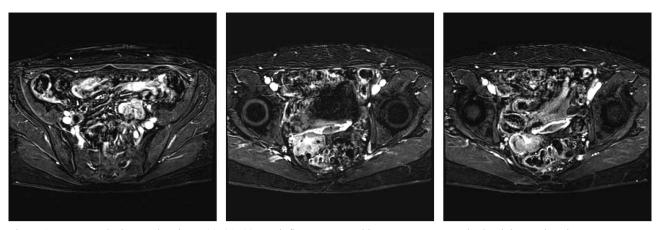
Presurgical MRI showing a 44×31×39 mm inflammatory and heterogeneous mass in the right ovarian site.
